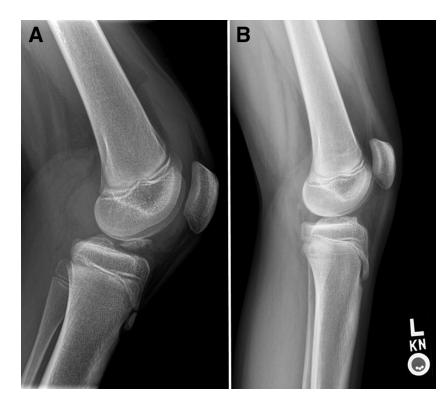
(A) Preoperative sagittal radiograph of a left knee demonstrating a type III tibial spine avulsion fracture. (B) Postoperative sagittal radiograph of the same left knee demonstrating complete healing after arthroscopic reduction and internal fixation of the fracture fragment.
